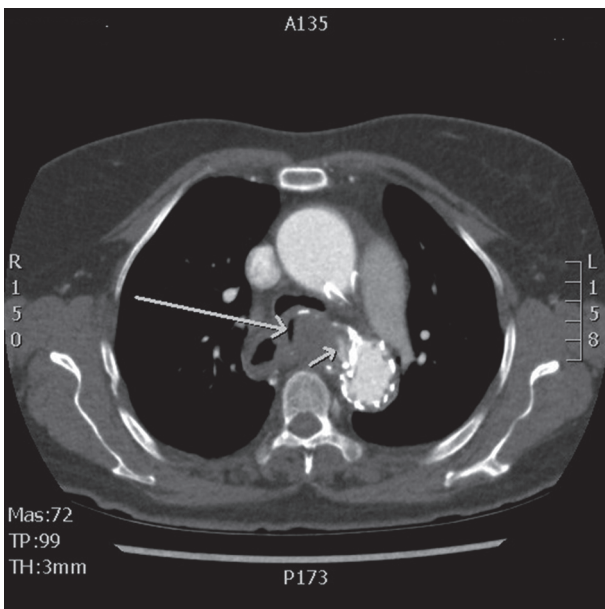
CT angiogram showing the endoprosthesis in the descending aortic arch with contrast medium leaking to the largely thrombosed aneurysm (48 x 37 mm) which implicates an endoleak (short arrow). The longer arrow points to the secondary aorto-esophageal fistula
